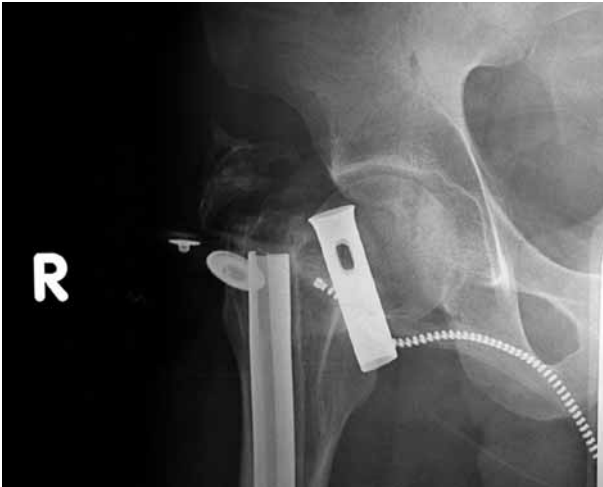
Anteroposterior radiograph of the right hip. The radiograph was taken with the patient not fully undressed (artefacts zip and two buttons). The trousers were cut off but not completely removed due to pain. Basicervical Garden IV fracture of the neck and nail fragment. Bony island over the greater trochanter.
